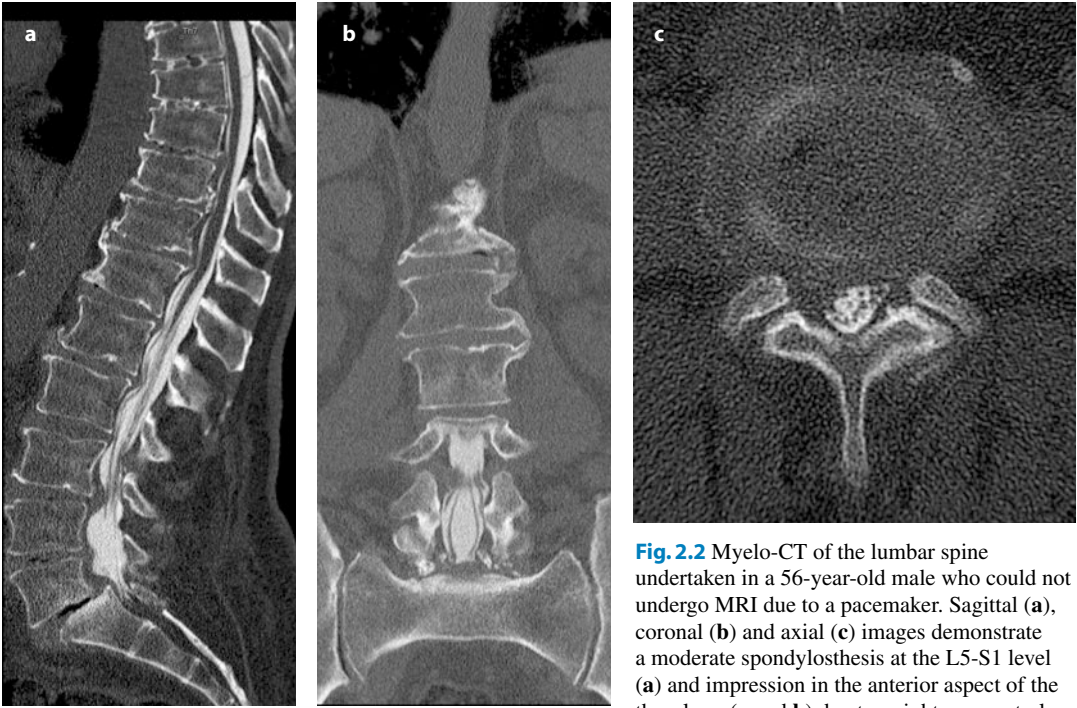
Myelo-CT of the lumbar spine undertaken in a 56-year-old male who could not undergo MRI due to a pacemaker. Sagittal (a), coronal (b) and axial (c) images demonstrate a moderate spondylosthesis at the L5-S1 level (a) and impression in the anterior aspect of the thecal sac (a and b) due to a right paracentral broad-based disk herniation impinging on the right L4 nerve root (c)
